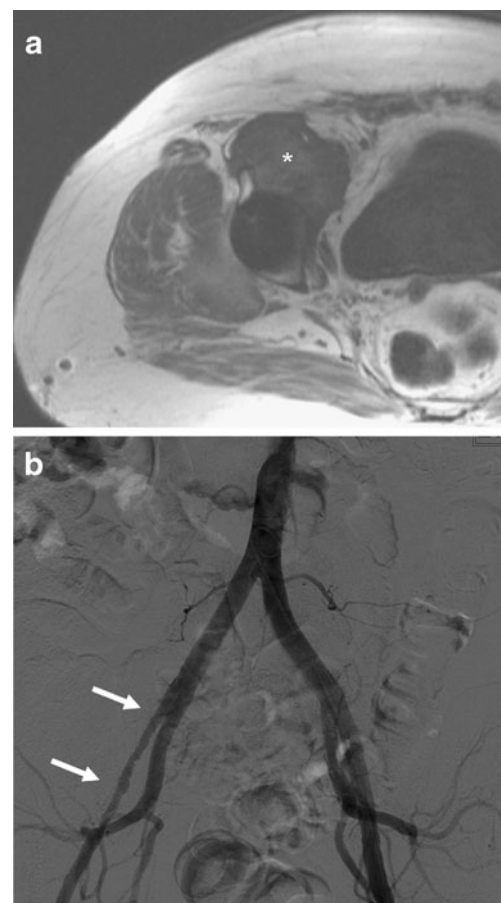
This patient initially presented with symptoms of femoral nerve compression and developed vascular insufficiency. a T1-weighted MRI showing reactive mass encasing the femoral neurovascular bundle (*asterisk*). b Arteriogram showing a stenotic segment of the right external iliac artery (*arrows*)
